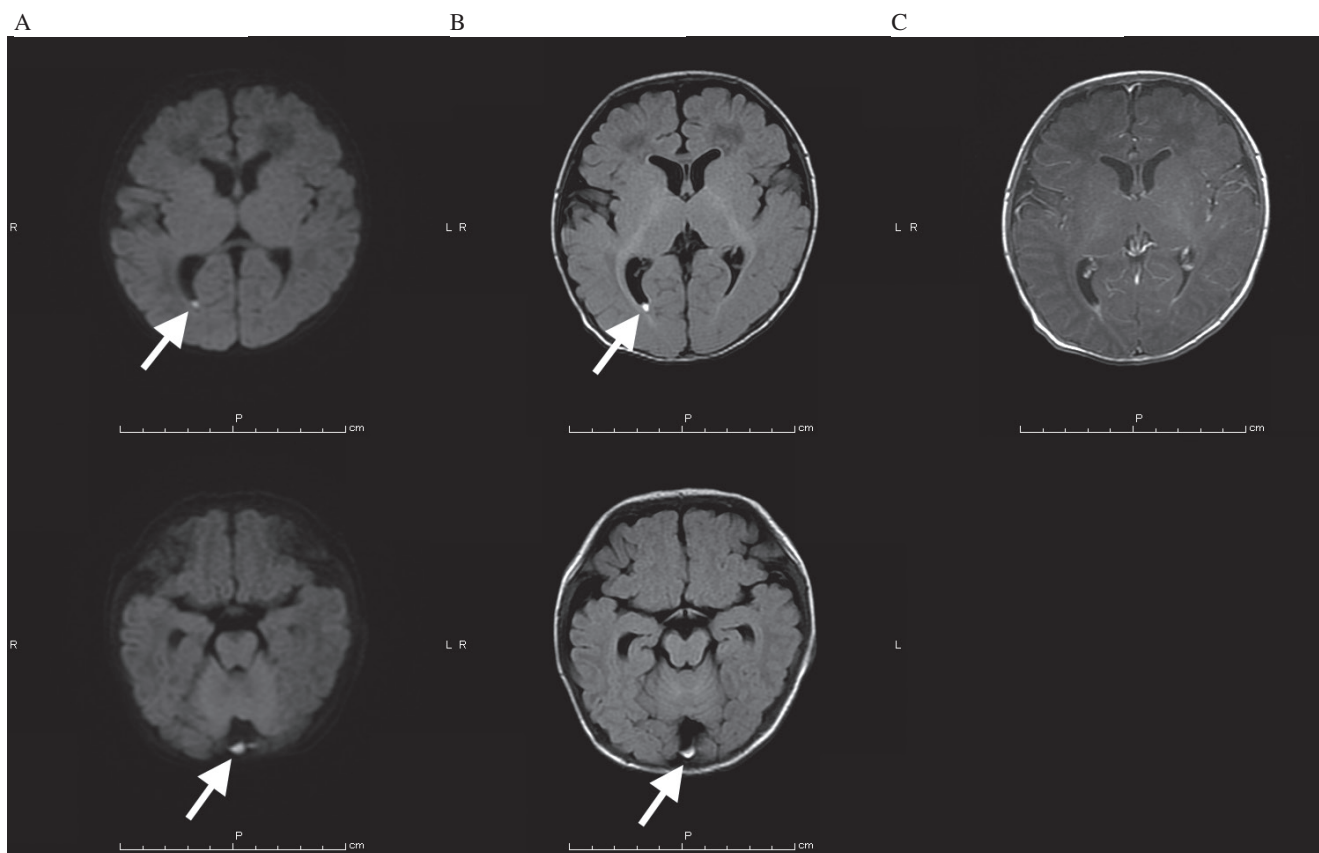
Head magnetic resonance imaging (MRI) on admission day 12. (A) Diffusion-weighted imaging. (B) Fluid Attenuated Inversion Recovery (FLAIR) imaging. (C) Gadolinium (Gd)-enhanced T1 weighted image. Diffusion-weighted imaging and FLAIR imaging showed hyperintense debris in occipital horn of the right lateral ventricle and the subarachnoid space of dorsal posterior cranial fossa. Gd-enhanced T1 weighted image showed surface of brain, fissure of brain, and ependyma enhancement with contrast.
